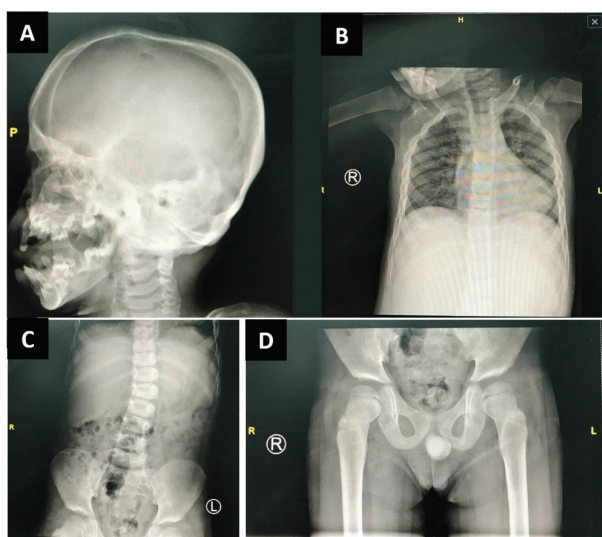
Skeletal X-ray showing mild dysostosis multiplex with A) thickened calvaria, B) bilateral mild broadening of the ribs, C) mild scoliosis, and D) shallow and irregular acetabulum.
